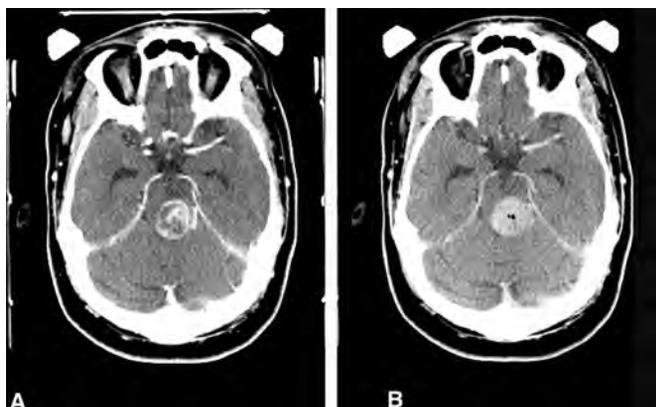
Medullary biopsy of this patient with a suspected central nervous system lymphoma is done by a transparachymal approach starting at the coronal suture. Air density at the target site verifies the biopsy site using intraoperative CT.
